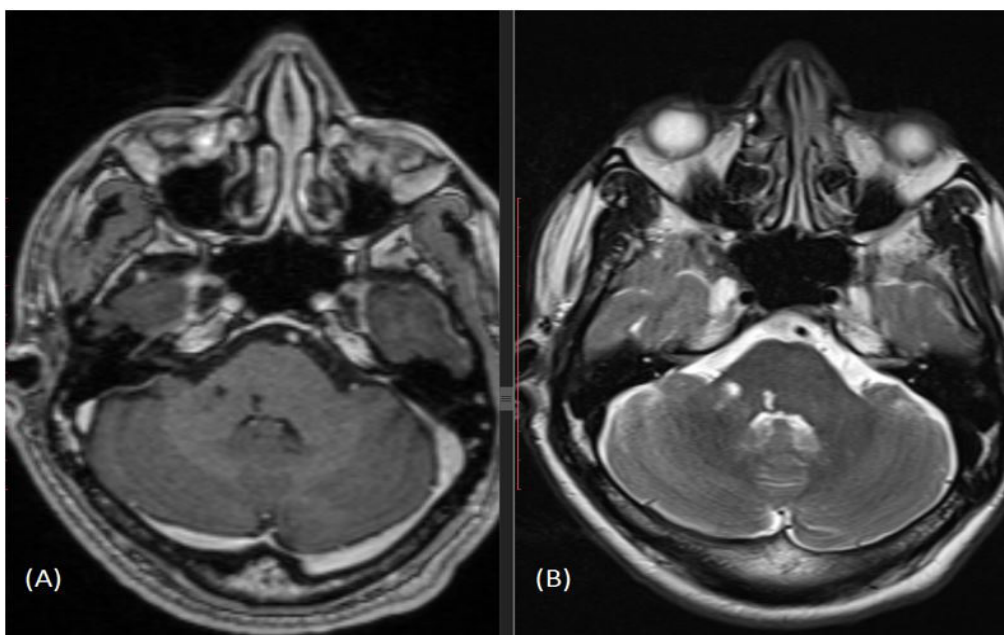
Brain MRI (Case 2). Brain magnetic resonance images performed twenty days after the stroke: A-T1 B-T2 sequences showing infarctions of the right dorsolateral pons and middle cerebellar peduncle (arrows). The images are compatible with embolic brainstem infarctions.
